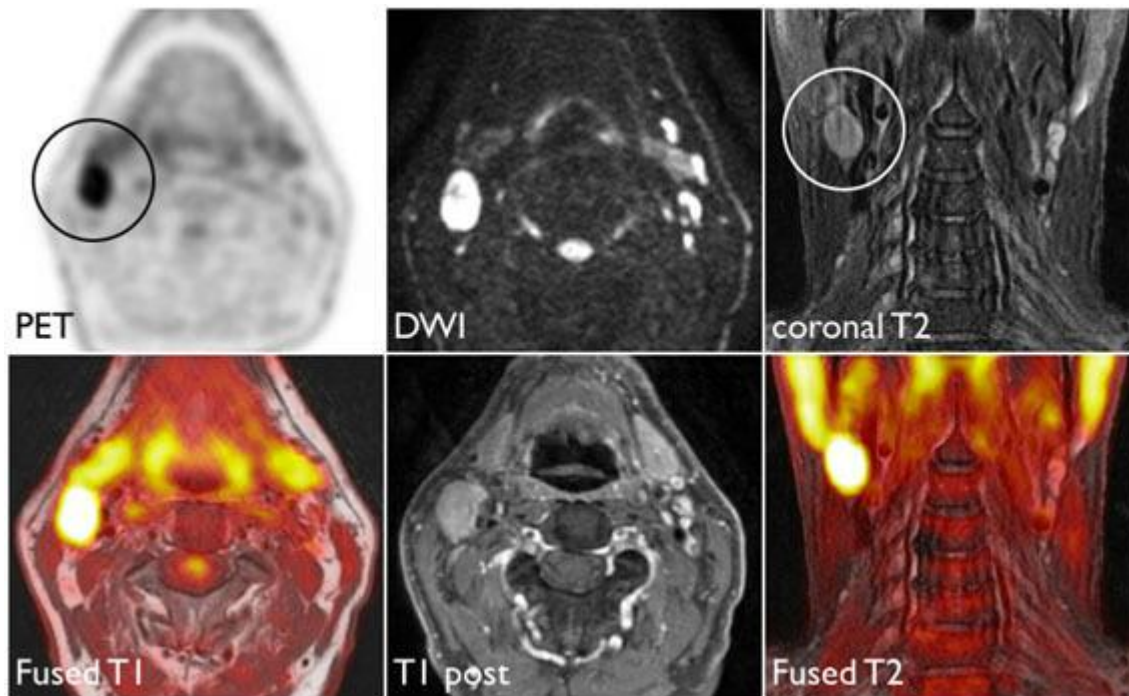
PET/MRI in a patient with head and neck cancer demonstrating a right cervical nodal metastasis (circle).
